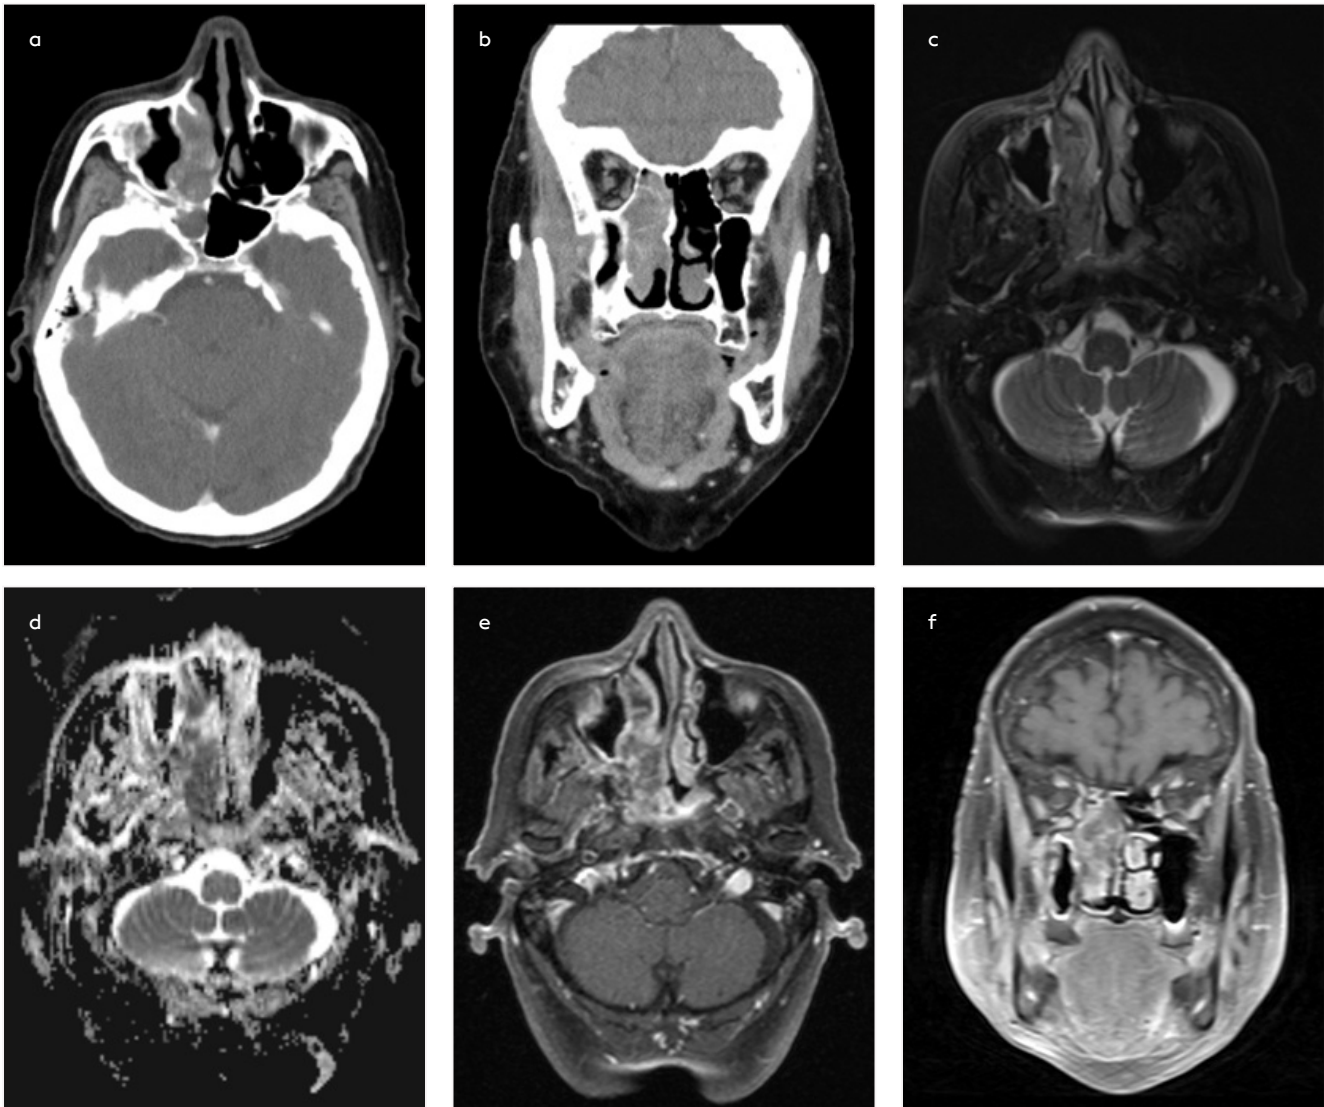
a-f. A 71-year-old female patient with primary EHNL (NHL, Diffuse large B-cell lymphoma, stage IE) in sinonasal cavity, received chemoradiotherapy and relapsed 15 months. Contrast-enhanced axial (a) and coronal (b) CT images show a well-defined, irregular shaped soft tissue mass involving the right side nasal cavity, posterior ethmoid cells and sphenoid sinus. The mass lesion shows hyperintense on axial fat-suppressed T2WI (c), restricted diffusion on DWI (d) and markedly heterogenous enhancement on axial and coronal contrast-enhanced T1WI (e, f).
